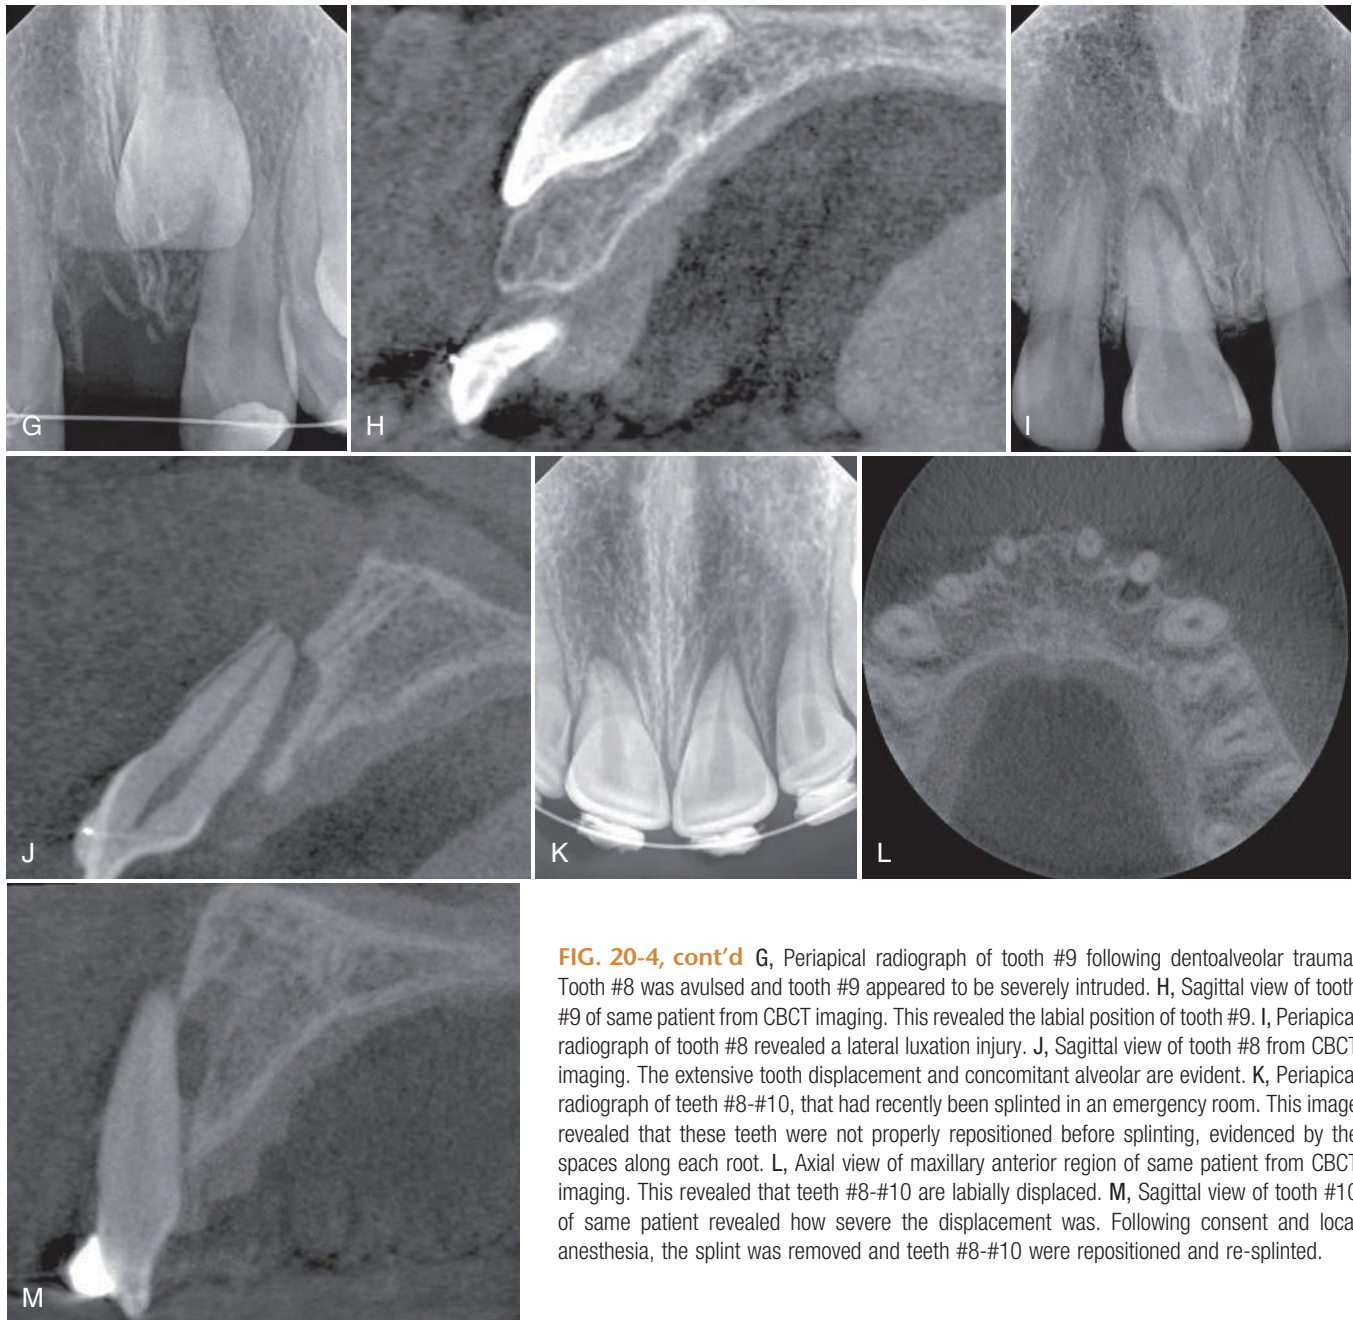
cont'd G, Periapical radiograph of tooth #9 following dentoalveolar trauma. Tooth #8 was avulsed and tooth #9 appeared to be severely intruded. H, Sagittal view of tooth #9 of same patient from CBCT imaging. This revealed the labial position of tooth #9. I, Periapical radiograph of tooth #8 revealed a lateral luxation injury. J, Sagittal view of tooth #8 from CBCT imaging. The extensive tooth displacement and concomitant alveolar are evident. K, Periapical radiograph of teeth #8-#10, that had recently been splinted in an emergency room. This image revealed that these teeth were not properly repositioned before splinting, evidenced by the spaces along each root. L, Axial view of maxillary anterior region of same patient from CBCT imaging. This revealed that teeth #8-#10 are labially displaced. M, Sagittal view of tooth #10 of same patient revealed how severe the displacement was. Following consent and local anesthesia, the splint was removed and teeth #8-#10 were repositioned and re-splinted.
